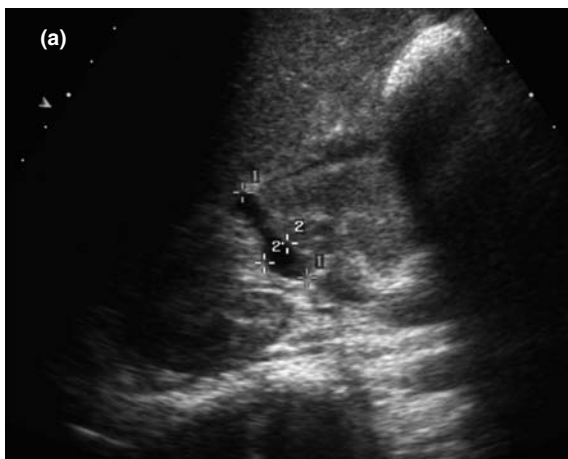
Renal trauma. (a) Ultrasound (US) shows a laceration in the mid part of the right kidney. (b) Repeat US 3 months later showing shrinkage of the lower pole and reduction in blood flow on Doppler. (c) DMSA appearances at 3 months in this patient.
